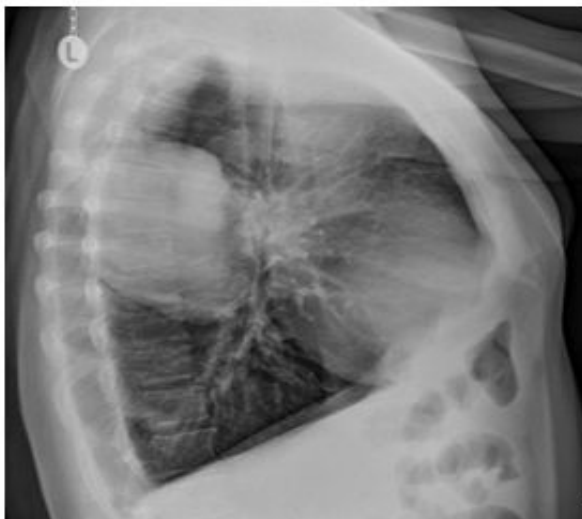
Chest X-ray, lateral view showing its demarcated growth in the right upper lobe.
